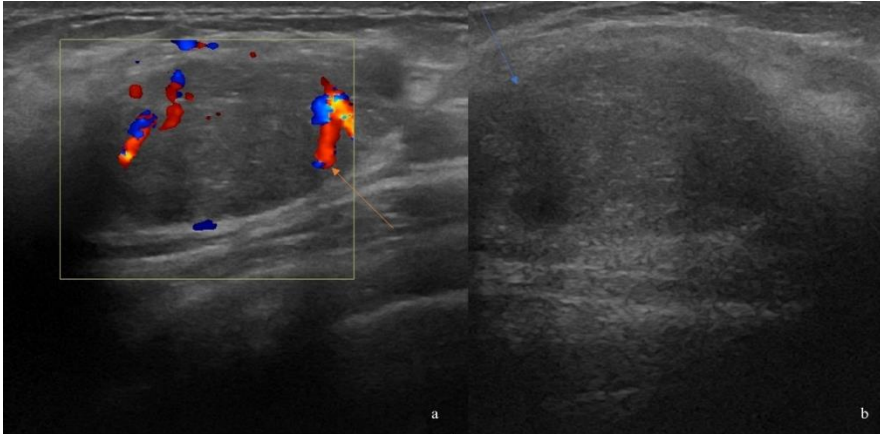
B and Doppler mode breast ultrasound: isoechoic, well-circumscribed fibroadenoma with central and peripheral Doppler signal (orange arrow) (a); B mode breast ultrasound: isoechoic fibroadenoma, with macrolobulated margins (blue arrow) (b)
